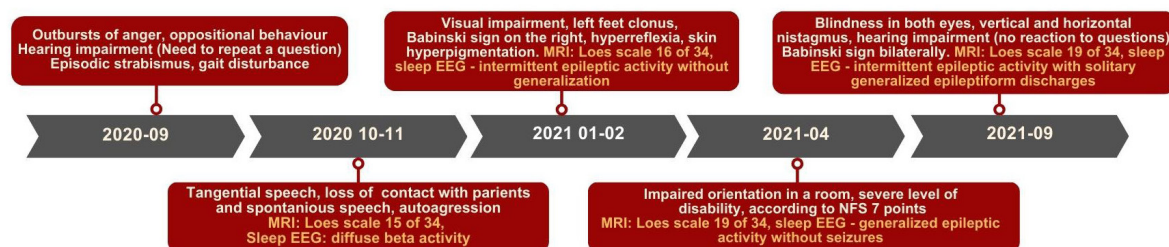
Timeline of symptoms, magnetic resonance imaging and electroencephalography of the patient
